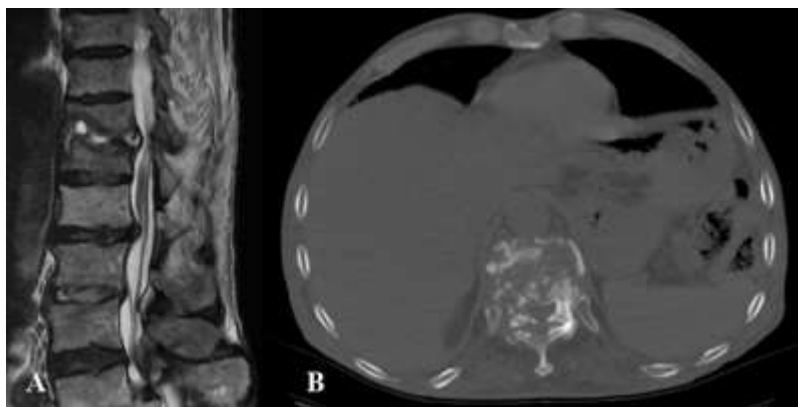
Pyogenic discitis and osteomyelitis of D11- D12 in a 67 years old male patient with back pain. A) Sagittal T2w MRI image shows D 11 - D 12 disco-vertebral complex morphological and signal changes consisting of erosion of vertebral endplates and fluid within the disc. The morpho-structural alterations determine the compression of the adjacent anterior epidural space and the anterior portion of the medullary cone, with myelopathy signs at the same level; B) Axial CT image shows D11-D12 diffuse vertebral soma and peduncles destruction, evidence of diffuse abscesses that extend bilaterally in the paravertebral spaces.
